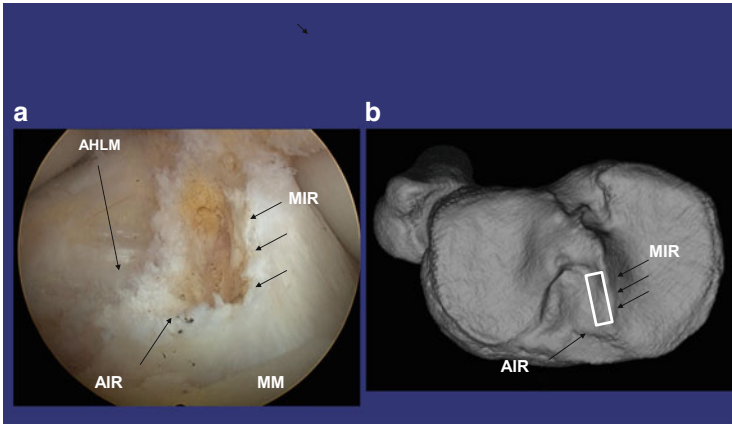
ACL tibial attachment area of the *right* knee. (a) Arthroscopic view via the anteromedial portal with a 45° arthroscope; (b) 3D CT view. There are three landmarks to identify the attachment area: medial intercondylar ridge (*MIR*), anterior intercondylar ridge (*AIR*), and anterior horn of the lateral meniscus (*AHLM*). *MM* medial meniscus
